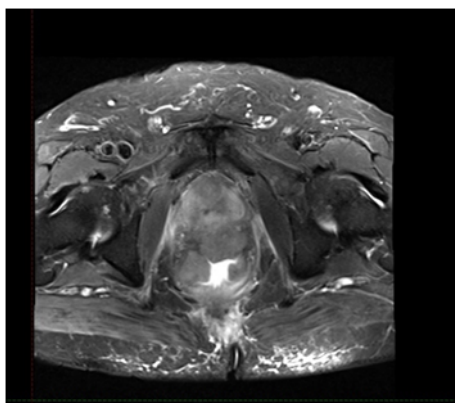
Axial MRI at the time of recurrence showing rectal mass with infiltration in prostate
